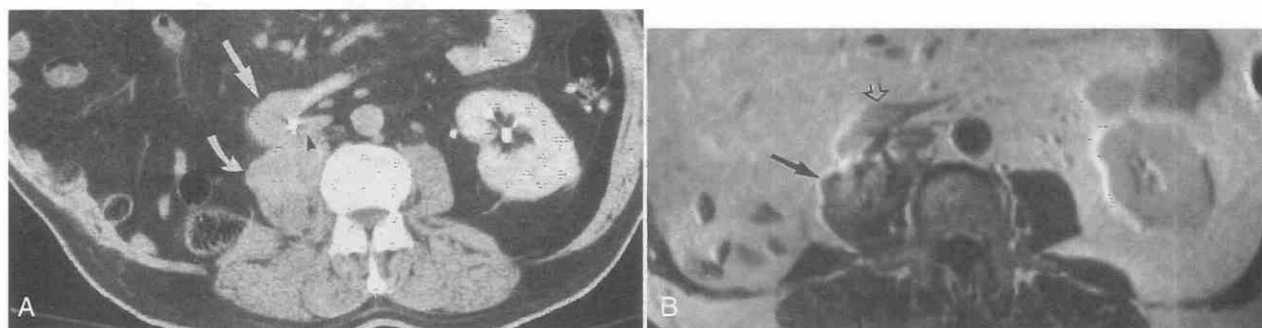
Local recurrence of renal cell carcinoma 7 years after nephrectomy for right renal cell carcinoma. Patient presented with upper gastrointestinal bleeding. *A*, An enhancing mass (*curved arrow*) causes enlargement of the right psoas muscle. The third part of the duodenum (*straight arrow*) and the inferior vena cava (*arrowhead*) are adherent to the mass. *B*, MRI (spin-echo, TR = 500 msec, TE = 15 msec) performed after IV injection of gadolinium-DTPA shows an enhancing mass (*arrow*) involving the right psoas muscle. Endoscopy with biopsy showed clear cell carcinoma invading the third part of the duodenum (*open arrow*).
